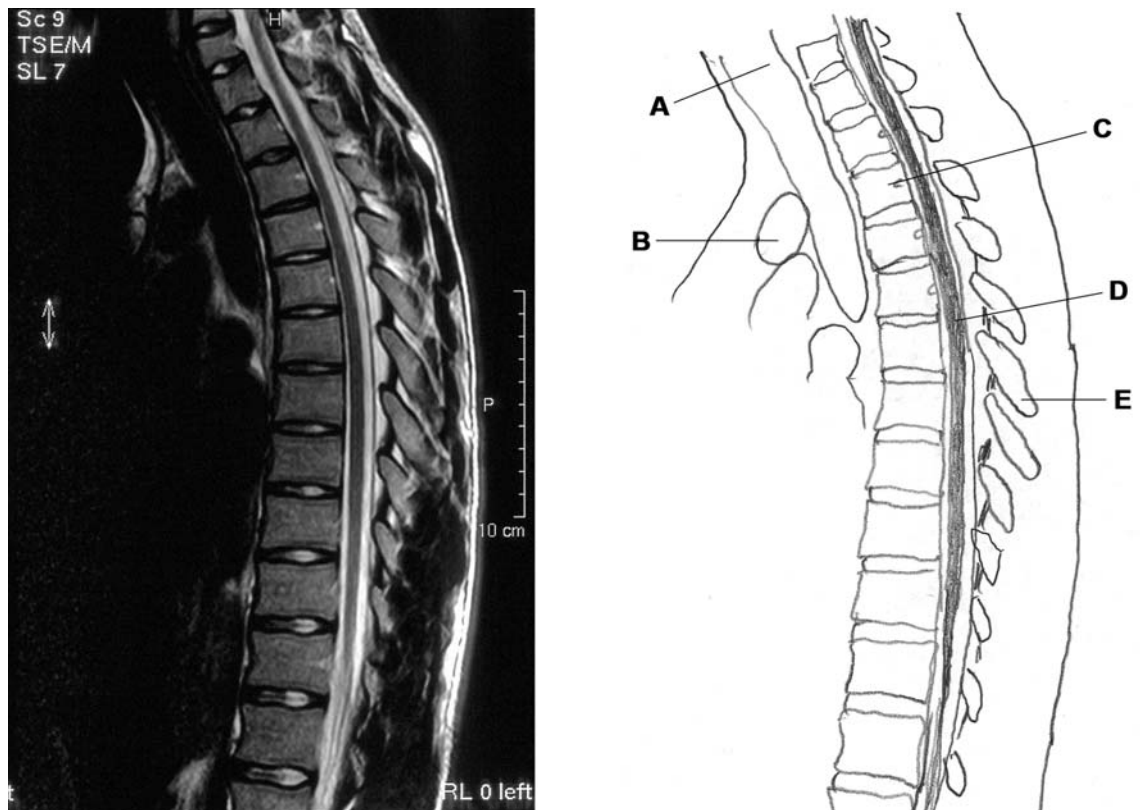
Sagittal T2-weighted image of the thoracic region from C7-T1 to mid-L2. Normal signal intensities of the vertebrae, spinal cord, and soft tissue. Fat and CSF are of the same signal intensity and are separated only by a thin dark line, the dura. A trachea, B supra-aortic vessels, C T3 vertebra, D spinal cord, E spinous process
